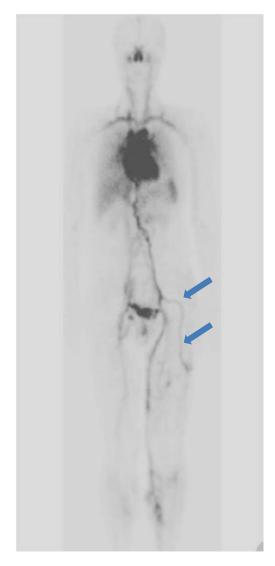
Tc-99 m RBC whole-body blood pool scintigraphy (WBBPS). WBBPS in a 44-year-old male patient with venous malformation (VM) in the left leg, which shows uptake defect in the deep vein and increased uptake in the great saphenous vein and marginal vein (*arrow*)
